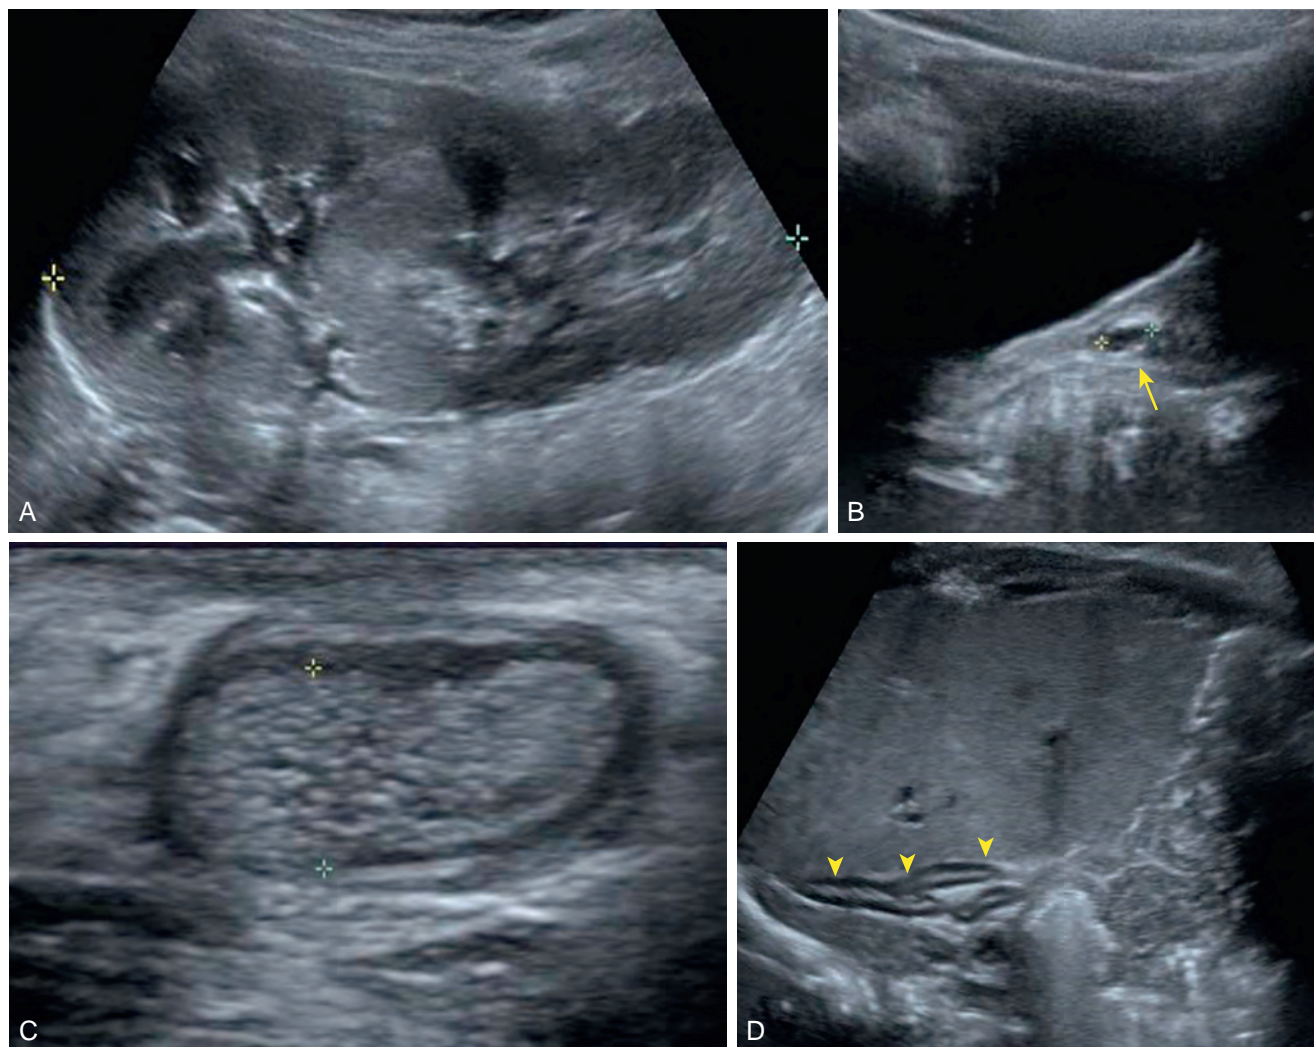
Four-year-old boy underwent left inguinal herniorrhaphy. No left vas deferens was present in the spermatic cord. A, Postoperative sonogram shows sagittal view of the solitary right kidney with duplicated collecting system. B, Sagittal view of the left seminal vesicle cyst (arrow). C, Sagittal view of left cystic dysplasia of the rete testis (between calipers). D, Sagittal view of an empty right renal fossa with a flattened or “lying down” adrenal gland in a neonate with right renal agenesis (arrowheads).
